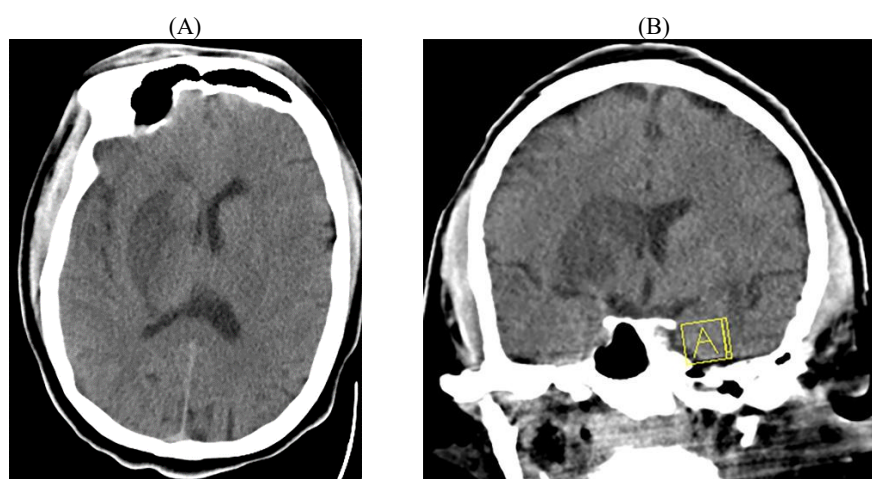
F/50. (A) Transaxial view, (B) Coronal view. This patient complained of a sudden onset of the Left hemiparesis. Non-contrast brain CT shows an ischemic brain infarct of the lentiform nucleus of the right basal ganglia.
